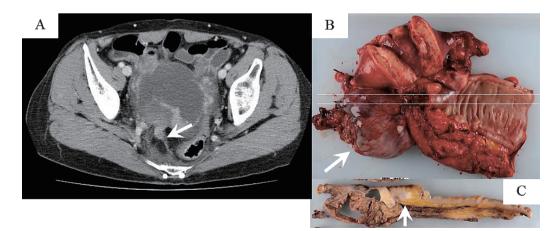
Abdominal computed tomography shows right ovarian recurrence in the pelvic portion (upper white arrow, A), recurrence in the pouch of Douglas (lower white arrow, A), the resected right ovary (B), and the carcinoma in the cleavage plane (C).
